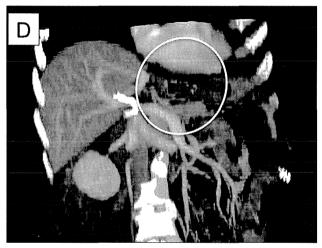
(A) Application and (B) firing of the endo-stapling devices. (C, white arrowheads) The major gastroesophageal shunt vessels (D, white circle) were eradicated, as confirmed by CT with 3-dimensional reconstruction.
